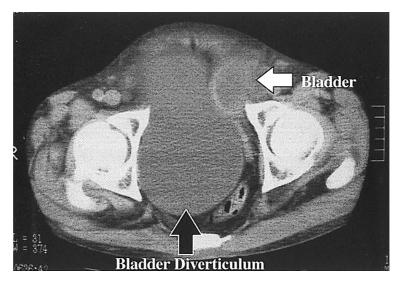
Abdominal CT scan demonstrating a large cysticlesion with a septum-like structure in the pelvis . The bladder is displaced to the left by diverticulum
